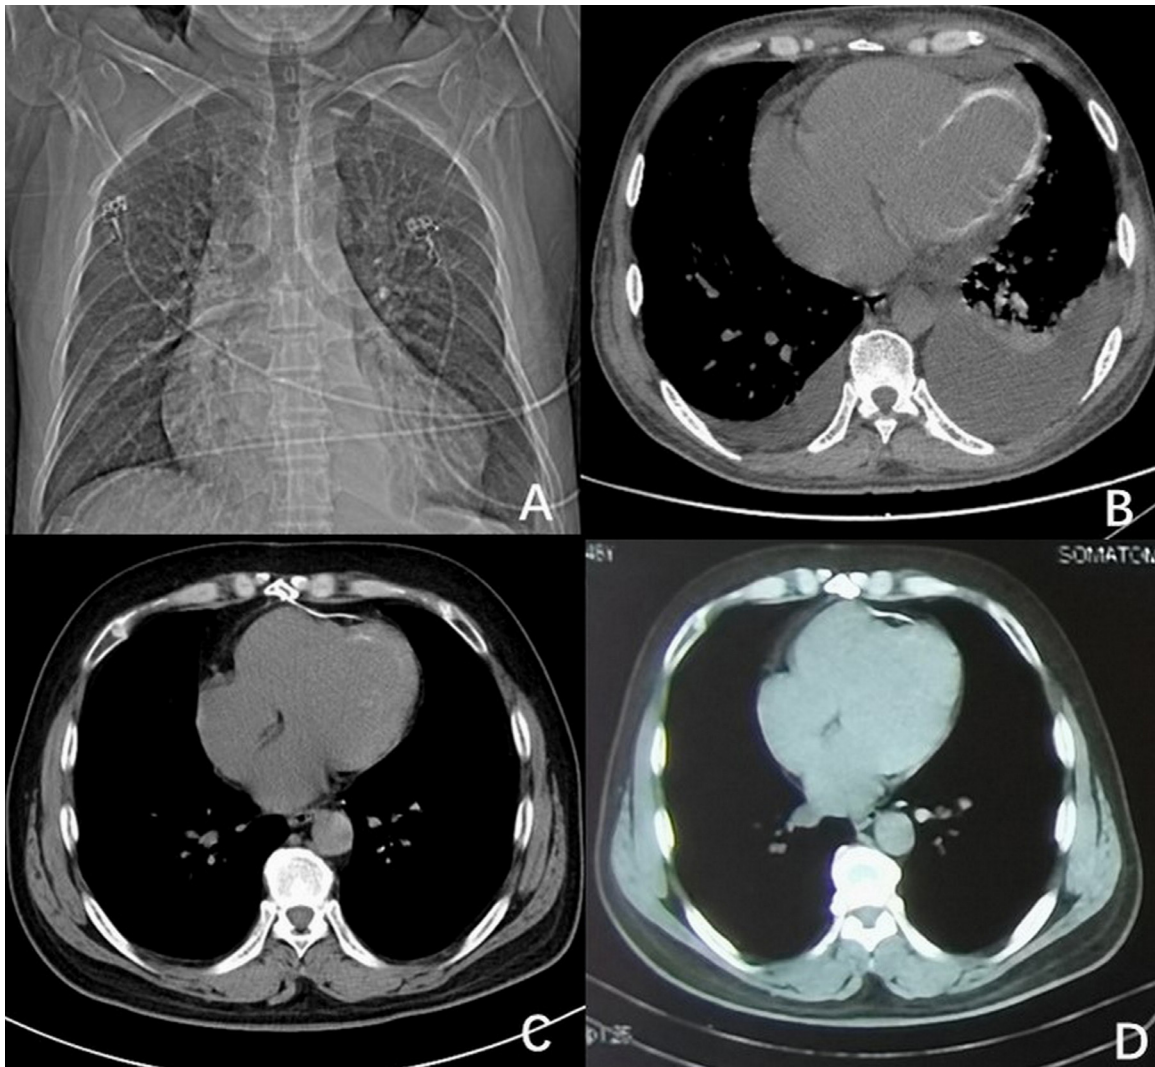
A) Chest X-ray showing no calcification at the border of the cardiac silhouette at disease onset. B) CT two months after onset showing calcification of the left ventricle and interventricular septum. C) CT 12 months after discharge showing a significant reduction in diffuse calcification of the left ventricular wall. D) CT 36 months after discharge showing complete resorption of calcification deposits in the heart.
